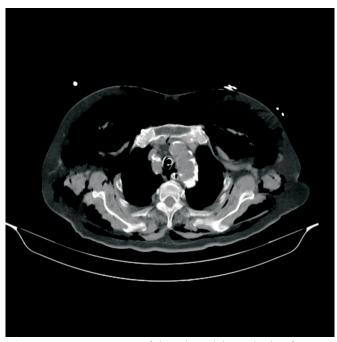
Transverse view CT of chest showed the tracheal perforation.
